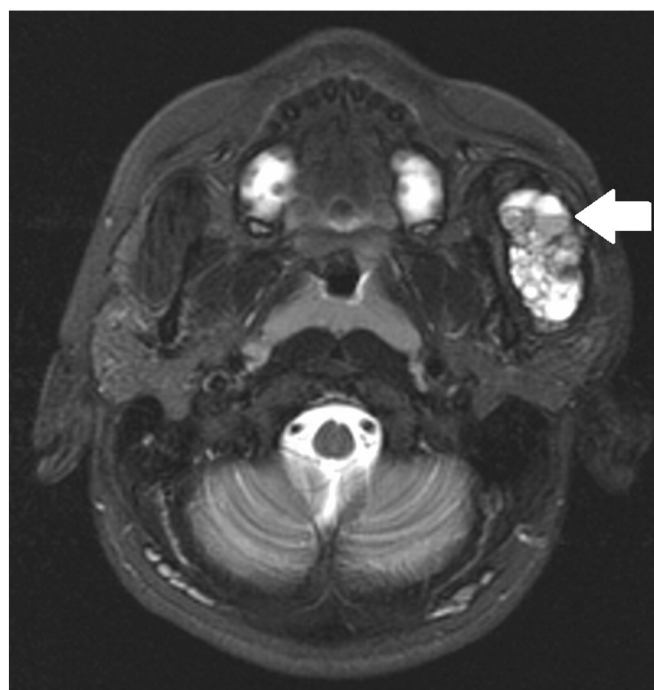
Axial short-tau inversion recovery (STIR) MR image. The fluid-fluid levels are clearly visible, due to blood sedimentation (arrow). High signal intensities inside the lesion indicate the cystic fluid component.
